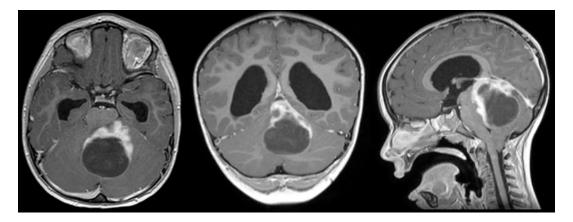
(Left to right) Axial, coronal, and sagittal post-contrast, T1-weighted MRI of classic JPA with enhancing mural nodule and cystic component
